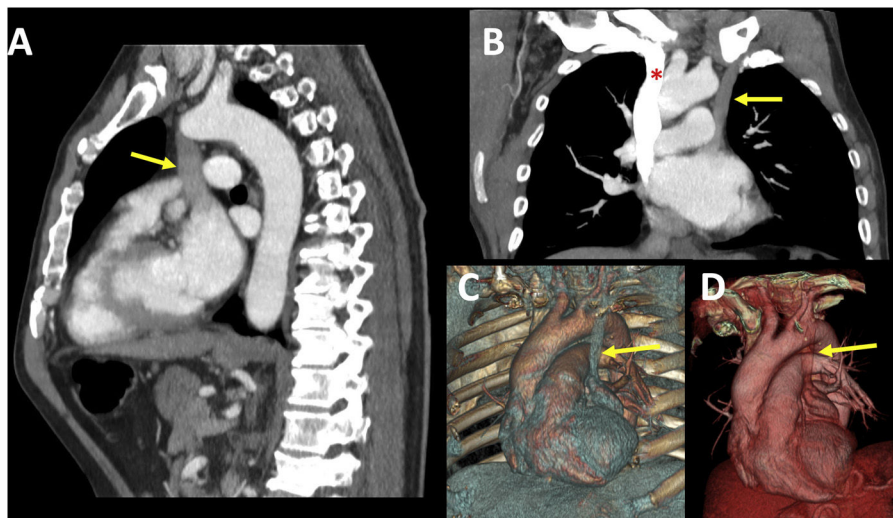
Sagittal (A), coronal (B) and volumetric (C, D) CT reconstructions showing the persistent left superior vena cava (arrows), draining into the left atrium. The right superior vena cava is preserved (asterisk).
